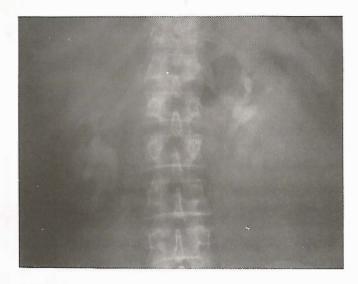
1. X-ray abdomen showing large soft tissue mass in left renal area.
